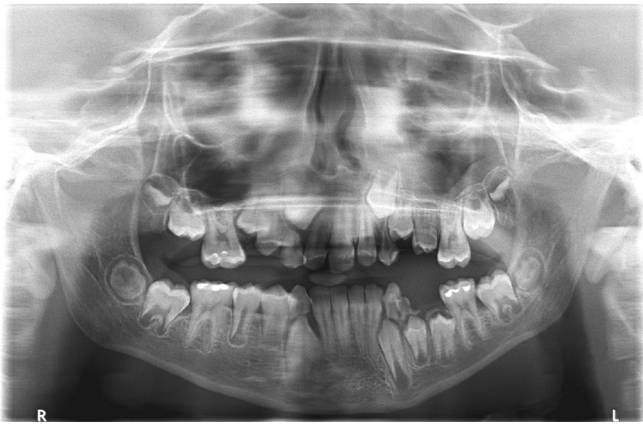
Patient's panoramic radiograph
